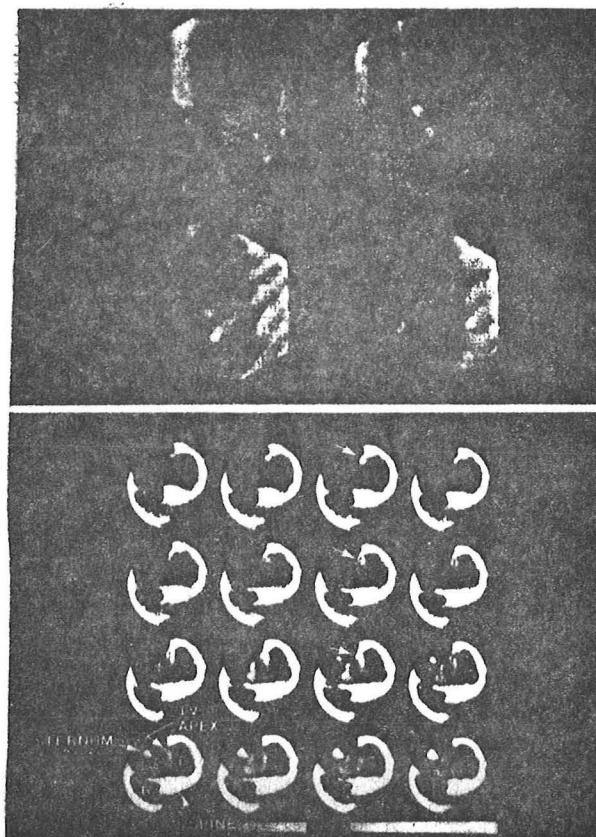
Planar (top) and SPECT images of a non-Q-wave myocardial infarction (49).
